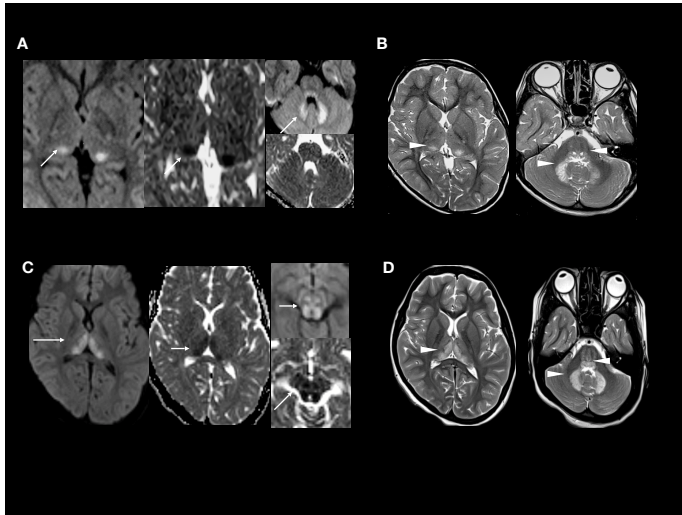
1 Brain MRI of Patient 1 at 13 years (A,B) and follow up after a month (C,D,E,F). A. Symmetrical areas of high signal on Diffusion-Weighted Images(DWI)(arrows) with lack of true restricted diffusion and normal Apparent Diffusion Coefficient (ADC) in the medial thalami, periaqueductal grey matter, brainstem and dentate nuclei. B. T2 hyperintensities (arrowheads) in the medial thalami, periaqueductal grey matter, brainstem and dentate nuclei. Follow up MRI after a month, post status epilepticus (SE) C. DWI/ADC images demonstrates new areas of restricted diffusion on(arrows) in the left cerebral white matter. Similarly in the right frontal & insular cortex (not in the image). D. DWI/ADC images demonstrate symmetrical areas of high signals on DWI and lack of true restricted diffusion in the thalami. E. DWI/ADC images demonstrate inhomogeneous mixed pattern of restricted and normal diffusivity in the brainstem and dentate nuclei. F. T2 hyperintense changes (arrowheads) in the bilateral thalami, left basal ganglia, brainstem and dentate nuclei.
